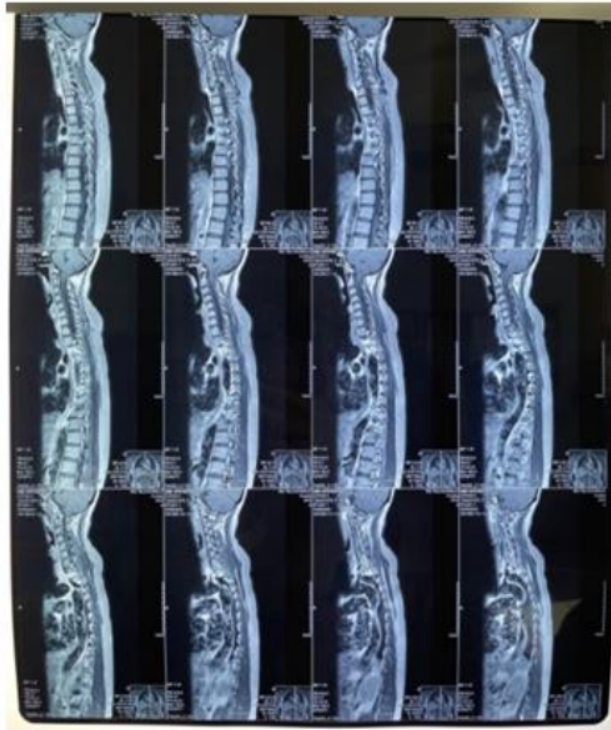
Cervicothoracic MRI with contrast in Case 2. The impression is still visible intramedullary lesions in the central canal at the level of V.C1-2 to Th 11-12 (non-enhanced)
